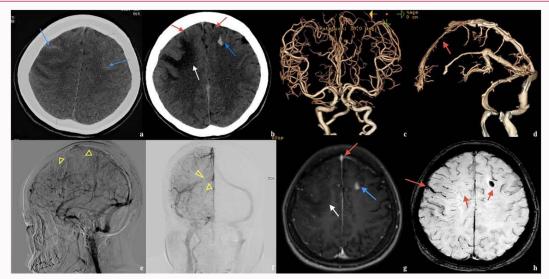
(a) axial non-enhanced CT on day 2 shows the convexal SAH in the frontoparietal sulcus (blue arrow), (b) axial non-enhanced CT on day 8 shows the convexal SAH in the frontoparietal sulcus (red arrow), parenchymal hemorrhage (blue arrow), cortical edema (white arrow) (c,d). The computed tomography arteriology shows no aneurysm or stenosis, computed tomography venography shows the filling defect in the Superior Sagittal Sinus (SSS). (e,f) DSA shows the filling-defect in SSS and right Transverse Sinus (TS), which confirmed CVST (yellow triangle). (g) Axial T1 shows the hyperintensity in SSS (red arrow), parenchymal hemorrhage (blue arrow), hypointensity, which means cortical edema (white arrow) (h). The SWI shows microbleeding (short red arrow) and dilation of cortical vein in the right frontal lobe (long red arrow).
